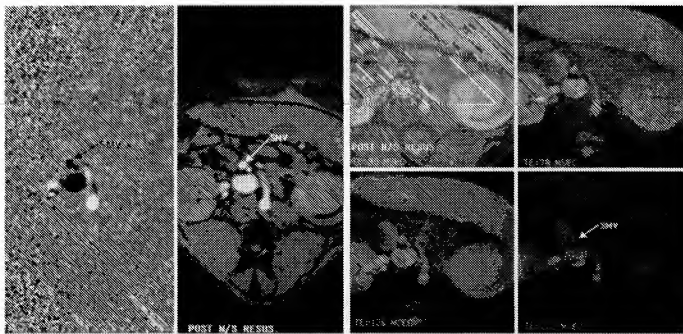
MR images from a typical experiment. (a) Peak systolic cine phase-contrast velocity (left) and magnitude (right) images (25/10, 30° flip angle) obtained at baseline. (b) Images (2,000/30, 78, 126, 222) obtained from the in vivo oximetry sequence at baseline. Even at an echo time (TE) of 222 msec, the signal intensity of SMV blood is still fairly high, which indicates a long T2 relaxation time and high %HbO<sub>2</sub>. (c) Peak systolic cine phase-contrast velocity (left) and magnitude (right) images (25/10, 30° flip angle) obtained after 30% blood loss (BL). Notice a marked decrease in the size of the SMV on the magnitude image and a decrease in the darkness of the SMV blood on the velocity image, which indicate a marked decrease in SMV blood flow as compared with baseline. (d) Images (2,000/30, 78, 126, 222) obtained from the in vivo oximetry sequence after 30% blood loss. Notice a decrease in signal intensity in the SMV blood on the late echo images, which indicates a decrease in SMV %HbO<sub>2</sub>. (Fig 2 continues.)
